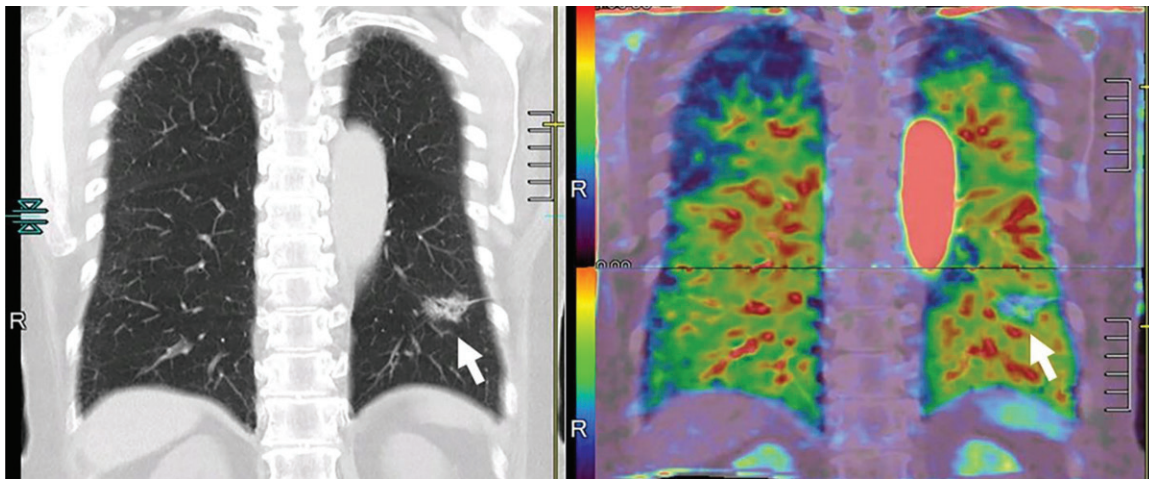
Images in a 73-year-old male patient with invasive adenocarcinoma (arrows) in the left lower lobe. Thin-section coronal multiplanar reconstruction image and quantitatively assessed whole-lung perfusion CT image (left) displayed as total perfusion map (right; combination of pulmonary arterial blood supply and systemic arterial blood supply from bronchial artery). Invasive adenocarcinoma (arrows) appears as part-solid nodule and decreased perfusion area compared with normal lungs. In addition, solid component shows relatively higher perfusion than ground-glass opacity. Whole-lung perfusion map was generated from two dynamic contrast-enhanced area-detector CT data sets by using our proprietary software.
